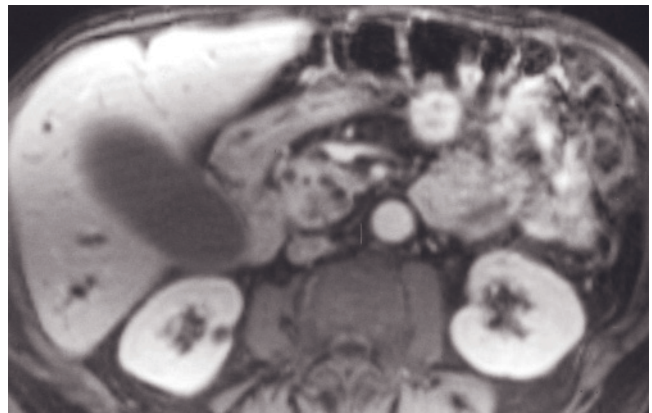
(Continued) patient with a poorly differentiated pancreatic adenocarcinoma arising in the head. Obstruction of the CBD (arrow, *c*) by the pancreatic head cancer is clearly shown on the coronal image (*c*). The pancreatic mass is mildly heterogeneous and hyperintense on T2-weighted (*c, d*) images, with minimal enhancement on early postcontrast images (*f*) and progressive enhancement on later images (*b*). The tumor partially encases the superior mesenteric vein (arrow, *b*), and a definable margin with a thin rim of adjacent pancreas (small arrows, *g*) is appreciated. Dusky of the fat around the superior mesenteric artery (arrow, *b*) is shown on the interstitial-phase gadolinium-enhanced fat-suppressed image (*b*). The coronal gadolinium-enhanced fat-suppressed image shows a patent portal vein (arrow, *i*) and its relationship with the cancer. Coronal T2-weighted SS-ETSE (*j*), immediate post-gadolinium T1-weighted SGE (*k*), and 90-s postgadolinium fat-suppressed SGE (*l*) images in a third patient with pancreatic cancer. Obstruction of the CBD is present. A hypoenhancing tumor (arrow, *k*) with definable margins with adjacent pancreas is clearly shown on the immediate postgadolinium image (*k*), which has central necrotic areas and causes biliary tree dilatation.
